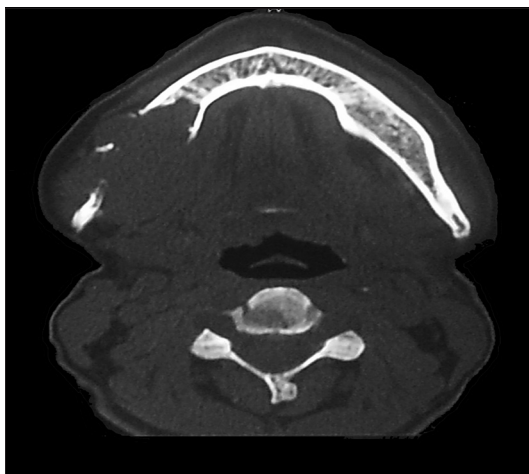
Axial bone window section on computed tomogram scan showed the expansile mass in the body of the mandible
